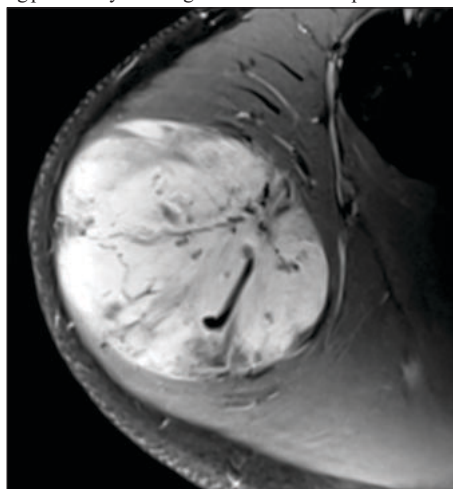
MRI Showing Mass In Deltoid Muscle With Myxoid Component
